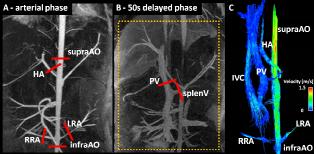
Contrast-enhanced MR angiography performed with gadofosveset (Ablavar) for anatomic overview and placement of 2D PC MRI planes (red). The PC VIPR acquisition volume (dashed yellow line) was prescribed such that it was centered over the liver and the locations of the 2D PC locations were covered. Hemodynamic visualization (C, 3D streamlines) are simultaneously available. HA=hepatic artery; PV = portal vein; splenV = splenic vein, supraAO = supra-celiac Aorta, infraAO = infra-renal arota; RRA = right renal artery; LRA = left renal artery.
